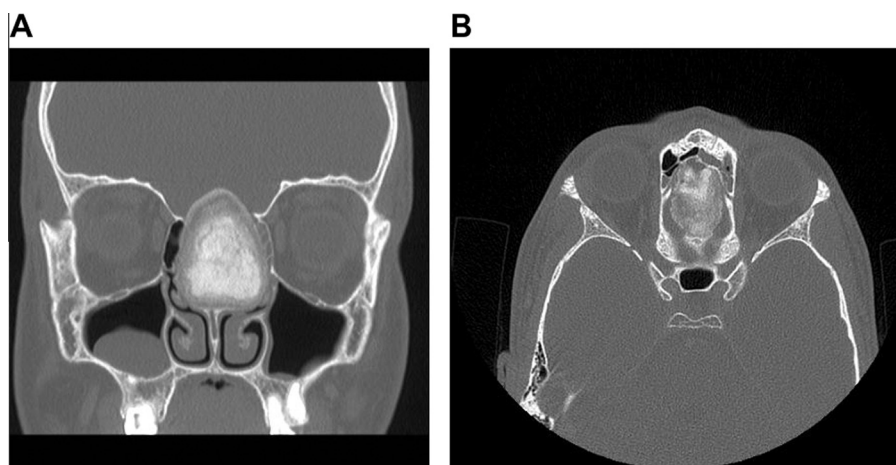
Pre-operative CT images. (A) Image with coronal section shows a huge fibrous dysplasia in nasal septum reaching through the skull base. (B) Axial section shows the width of the tumour, which is passing from skull base defect.
